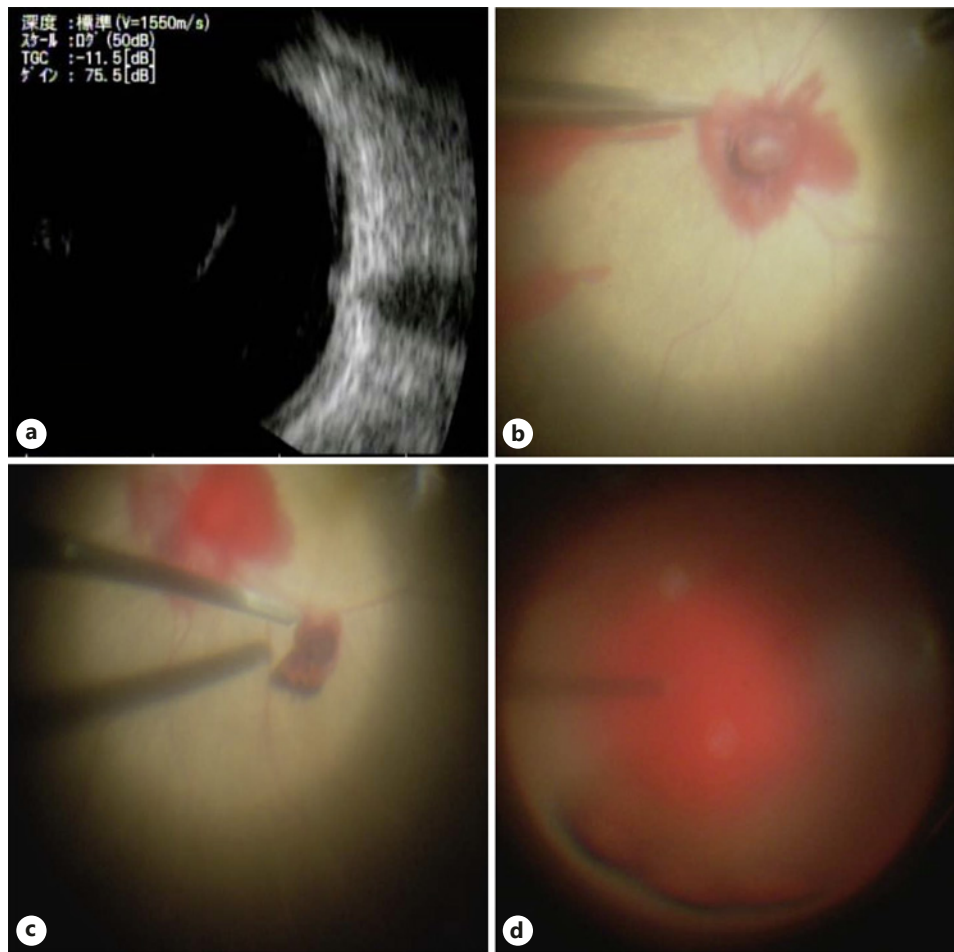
a B-mode ultrasonographic image of the left eye at the first clinical examination, showing vitreous hemorrhage without retinal detachment. A bulge on the optic disc can be observed. b After removal of the vitreous hemorrhage, an encapsulated hematoma can be seen on the optic disc. c Immediately after removal of the hematoma, the pulsating arterial bleeding could not be stopped. d An attempt to remove the pulsating arterial bleeding resulted in new vitreous hemorrhage.
